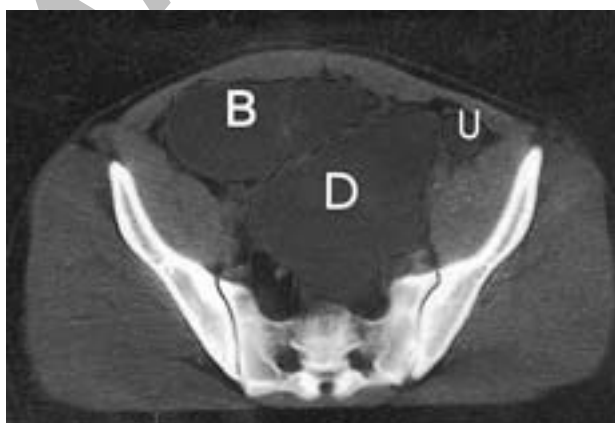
A slice from the abdominopelvic CT scan. B indicates the bladder; D, diverticulum; and U, the ureter.
